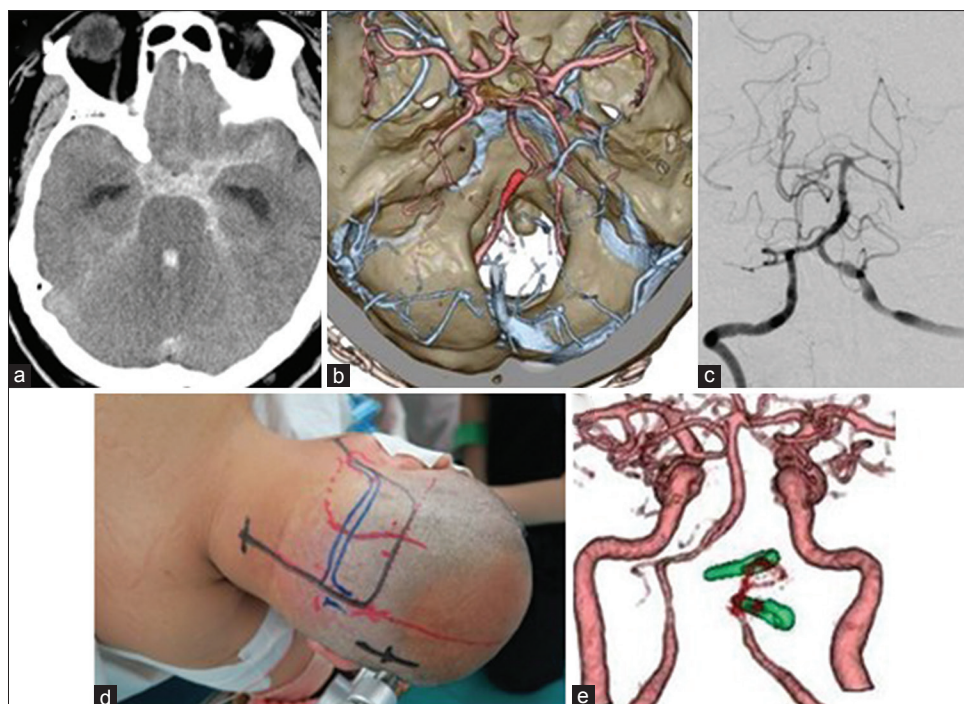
Case 9: (a and b) Preoperative three-dimensional computed tomography angiography showing a ruptured vertebral artery dissecting aneurysm on the left. (c) The dissecting lesion was located in the mid-sagittal position at just distal from the posterior inferior cerebellar artery bifurcation. (d) Emergent vertebral artery trapping through the transcondylar fossa approach was performed (e)
